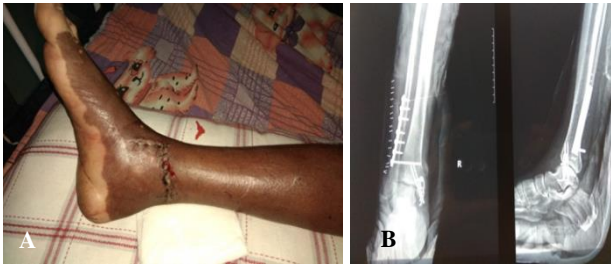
(A and B): Postoperative day 3 wound with postoperative X-ray.
